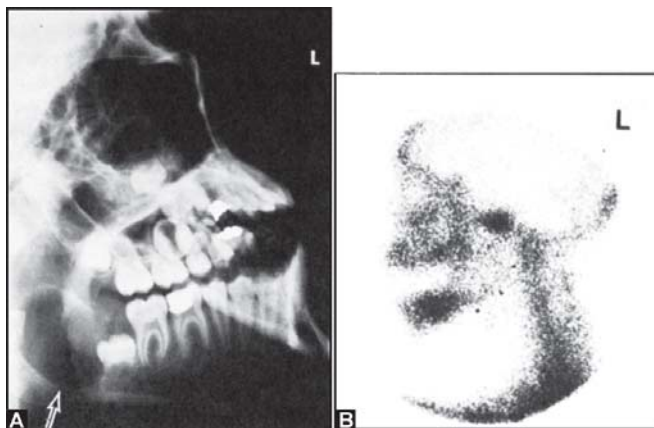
A. A 14-year-old female patient presented with a large asymptomatic cyst like lesion in the left mandibular ramus associated with an impacted third molar. A. Lateral oblique radiograph of the left mandible. B. Left lateral bone scan static image. Note the slight indication of undulation at inferior border of the lesion on the radiograph, and the substantial periapical pathology of the first molar. The scan shows an area of increased uptake in the mandibular body, probably reactive bone formation associated with the periapical pathology. An ill-defined area of diminished tracer uptake is seen in the ramus possibly surrounded, in part, by a thin border of increased uptake, a somewhat typical appearance for a bony cyst on a bone scan. Uptake is greatest at the inferior aspect, but this may be associated with the periapical pathology. The lesion proved to be a dentigerous cyst with a mural ameloblastoma at the inferior aspect
